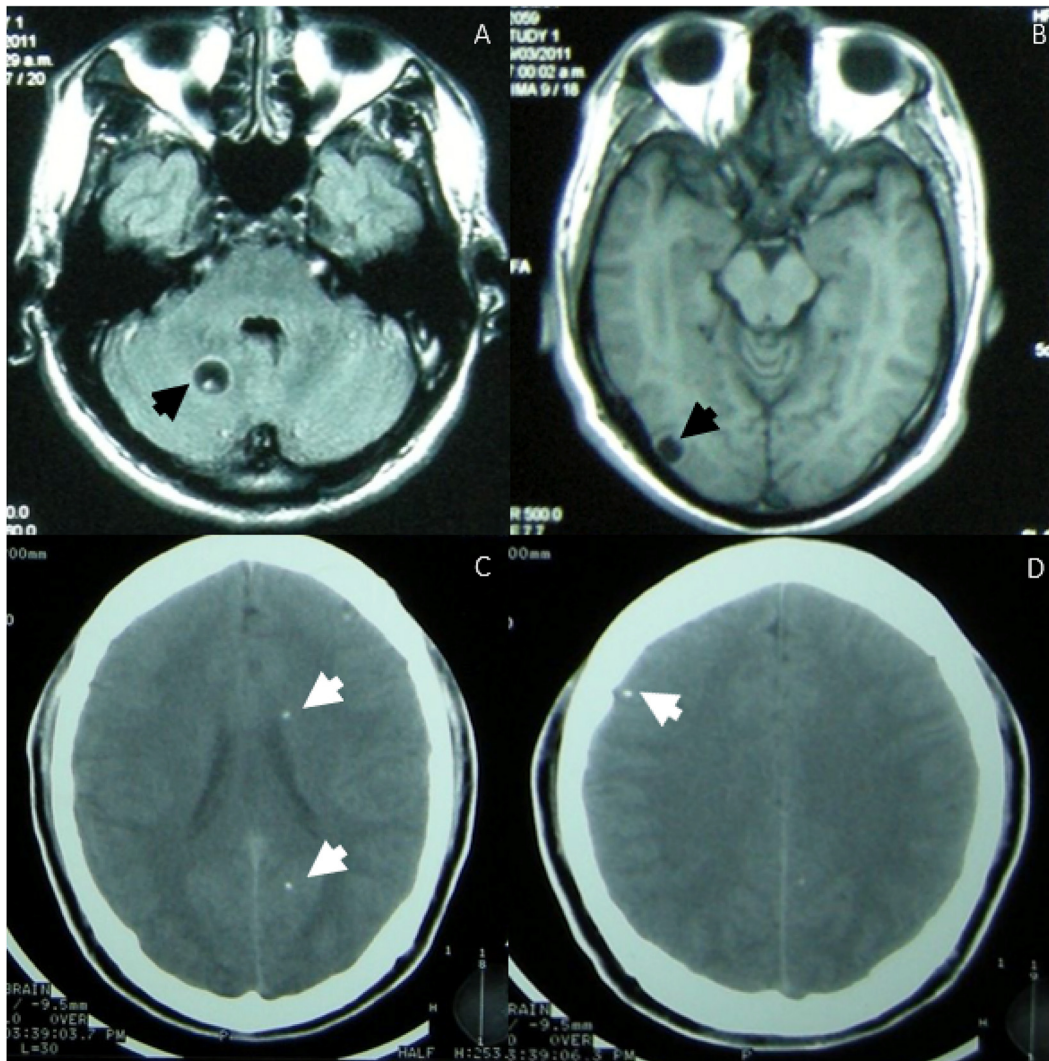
Neuroimages showing the characteristics of CNS cyst infection in a patient with parenchymal NCC. (A and B) Black arrows indicate viable cysts visualized using brain magnetic resonance imaging (MRI). (C and D) White arrows indicate calcified lesions on a computed tomography (CT) scan.
